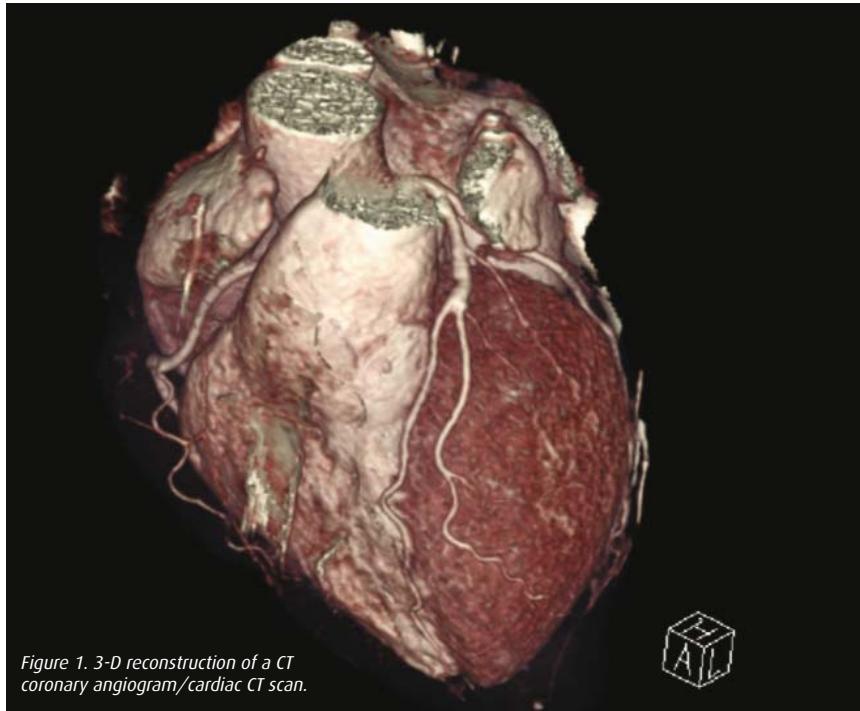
3-D reconstruction of a CT coronary angiogram/cardiac CT scan.
